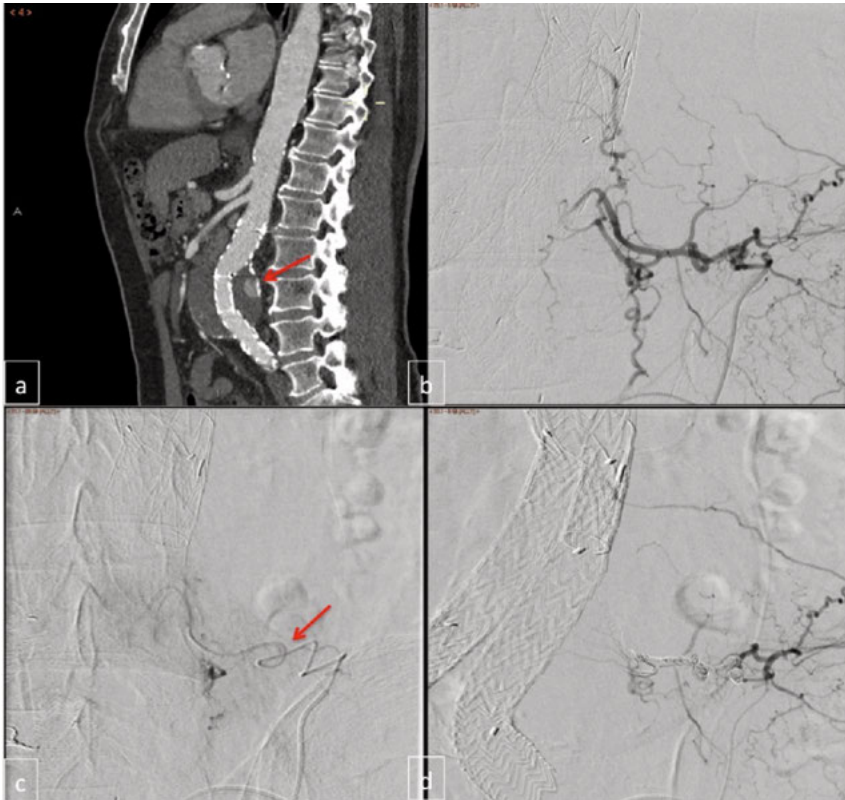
Endoleak type II on CTA (a) and DSA (b), catheterisation of the lumbar artery through the left internal iliac artery all the way to the aneurysm sac (c), disappearance of the endoleak after coiling (d).
